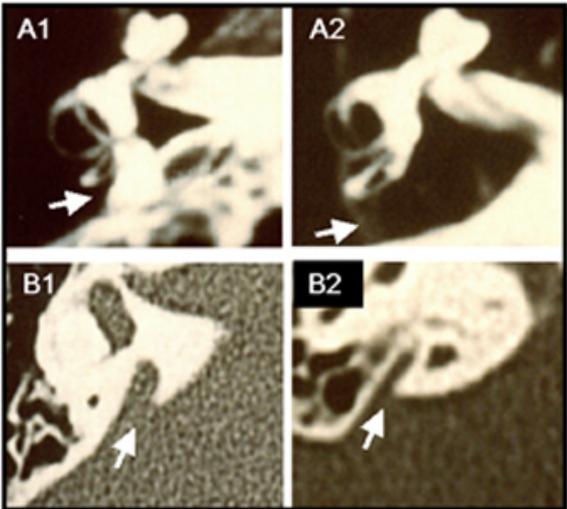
high resolution MRI section in a patient with Pendred syndrome (A1) and in a control (A2). Note the cochlea and the semicircular canals, and an enlarged endolymphatic sac that results, as expected, not visible in the normal control. The enlargement of the vestibular aqueduct at the CT scan of the petrous bone in one Pendred patient (B1) is shown, in comparison to the normal finding in a control (B2)
